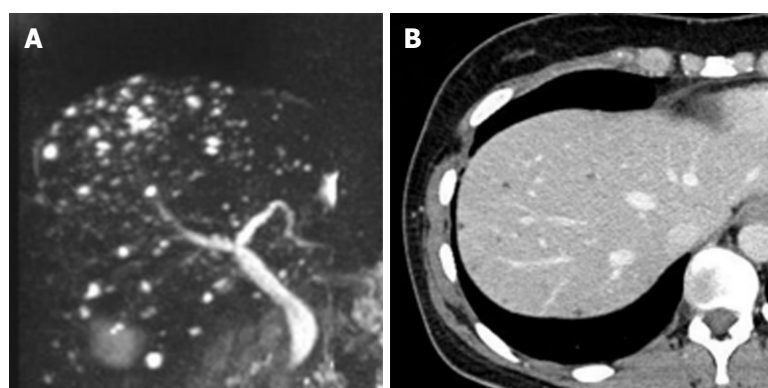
Magnetic resonance imaging and computed tomography scan of the donor. Magnetic resonance imaging scan of the donor shows 3-5 mm multiple nodules with high intensity in T2 weighted image (A). Her computed tomography scan also reveals multiple low-density area of 3-5 mm in diameter. Multiple biliary hamartoma, also known as von Meyenburg complex, was suspected.
